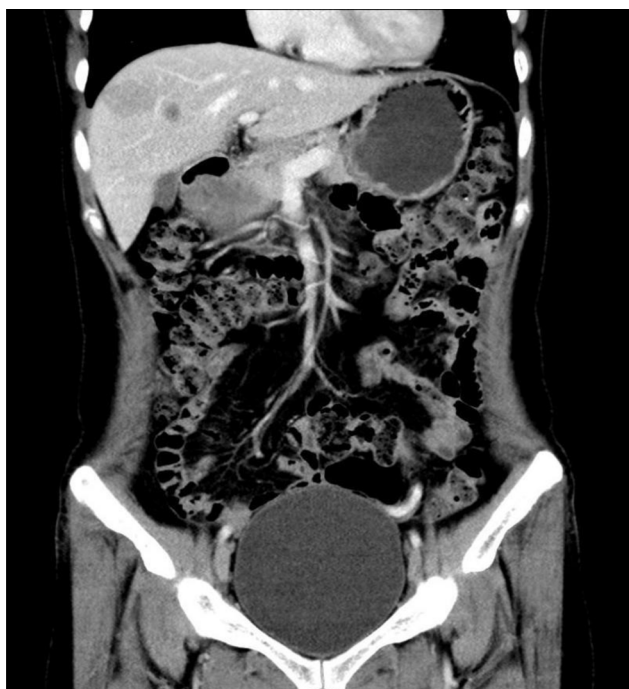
CT image during the portal phase showing two low-density lesions in the upper right anterior liver lobe (S8) (coronary view)
